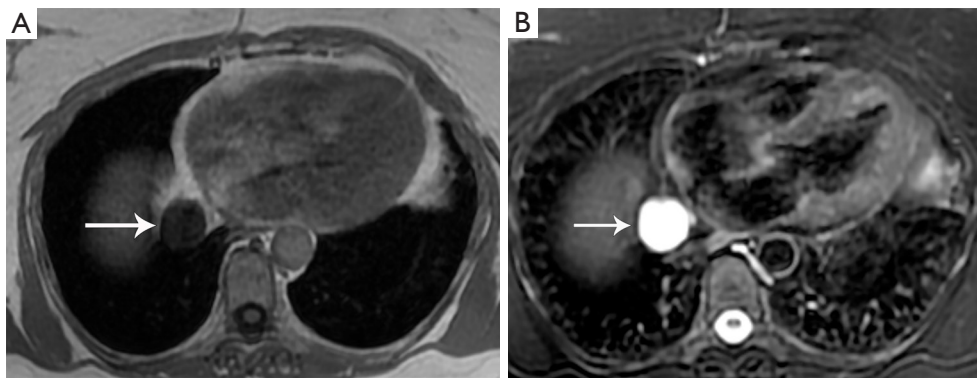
Pericardial cyst. (A,B) MRI images show typical low signal intensity on T1-weighted (A) and high signal intensity on T2-weighted (B) images of fluid (arrow) in the pericardial cyst. MRI, magnetic resonance imaging.
